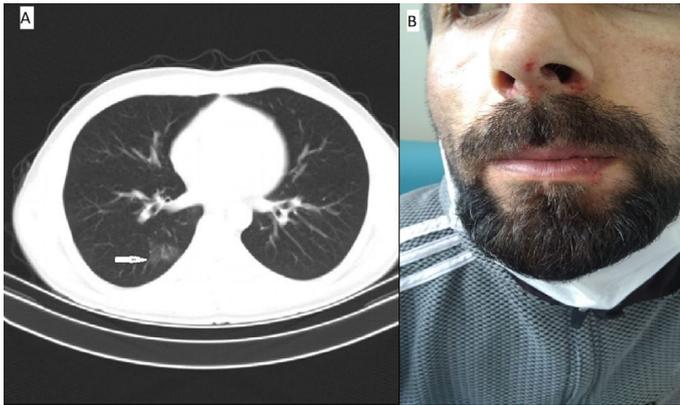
CT image of the case showing lung involvement (a) and lip picture indicating manifestation of the herpes simplex during COVID-19 (b)
